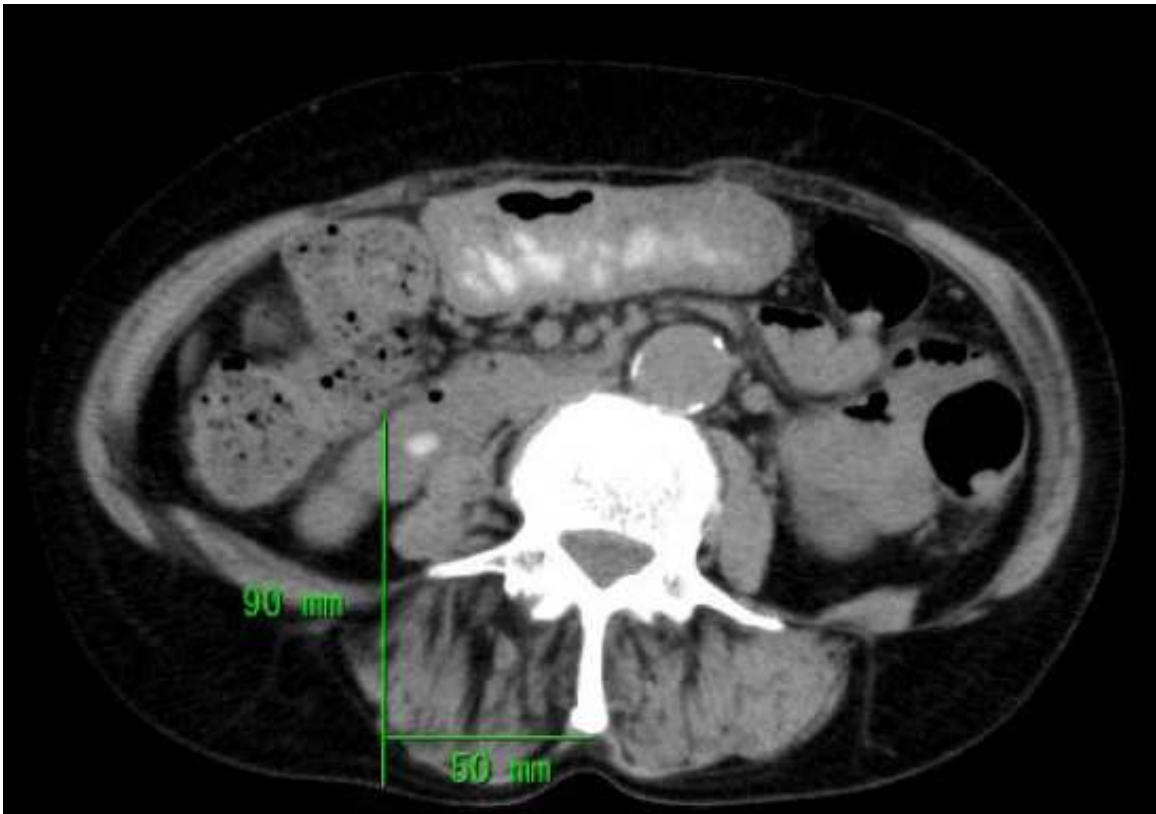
The computed tomography of a 70-year-old female at the 4th lumbar spine level. Note that if the needle had advanced as suggested by the textbook, it would have punctured the peritoneal cavity.
